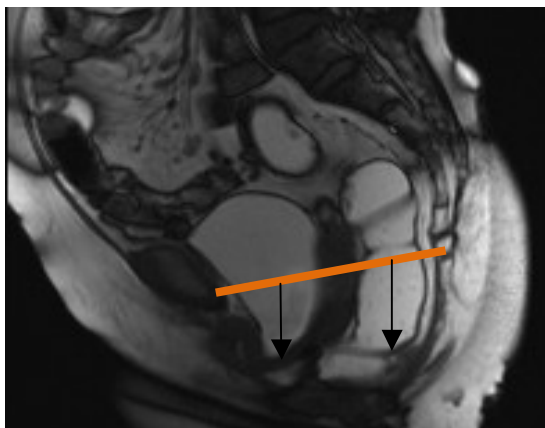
MRI Saggital T2 sections showing cystocele and pelvic floor descent*
